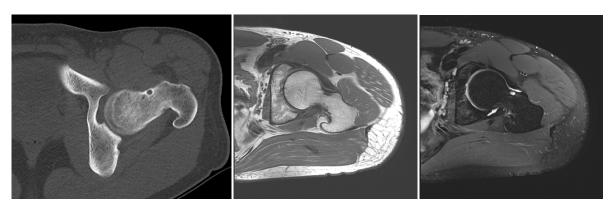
Herniation pit is showed a subcortical bony defect on CT(a), low-signal intensity on T1-weighted MRI(b) and a high-signal intensity with a lowsignal margin on T2-weighted MRI(c).
